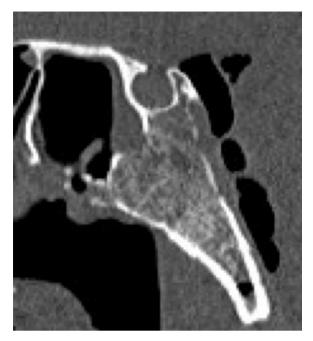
Preoperative sagittal head CT scan showing the necrotic bone of the clivus.
